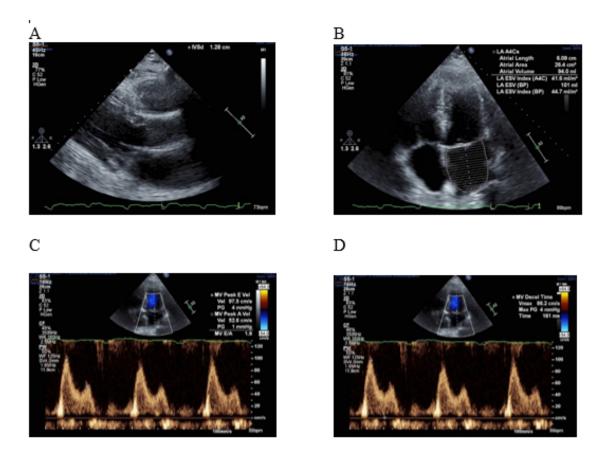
Echocardiography images showing diastolic dysfunction with a restrictive pattern with an elevated E/A ratio and decreased deceleration time (DT). A Mild left ventricle (LV) hypertrophy with an interventricular septum (IVS) of 13mm B Dilated left atrial (LA) with elevated LA volume index C Elevated E/A ratio D Decreased DT.
